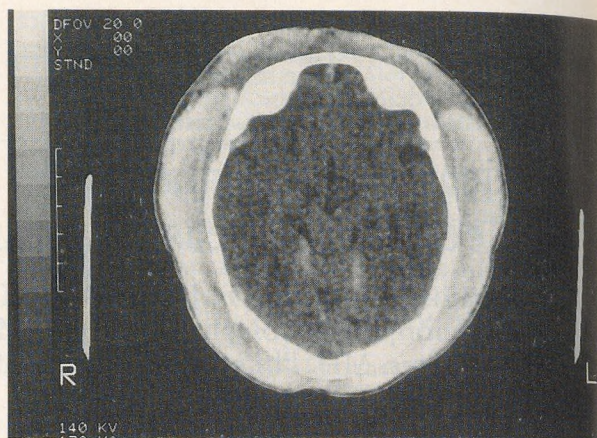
Computed tomographic head scan of the infant in case 2, demonstrating extensive scalp swelling resulting from subgaleal hematoma.
